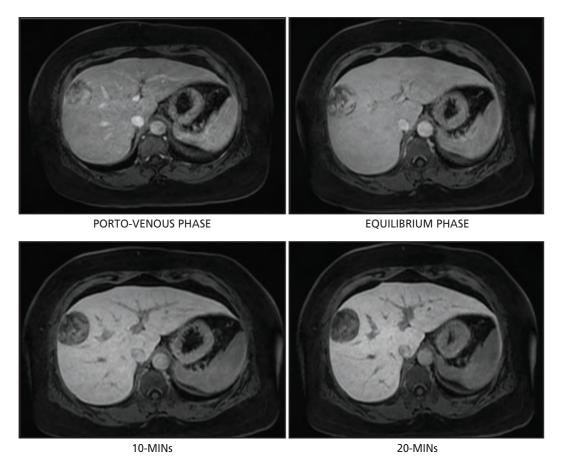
Magnetic resonance imaging (MRI) features of HAML: The mass is heterogeneously hyperintense on T2WI and hypointense on T1 fat-saturated image. The presence of significant signal drop on the opposed phase indicates fat content, with rim enhancement in the early arterial phase, progressive enhancement from the late arterial till equilibrium phases and hypointense in the 10-minute and 20-minute images
